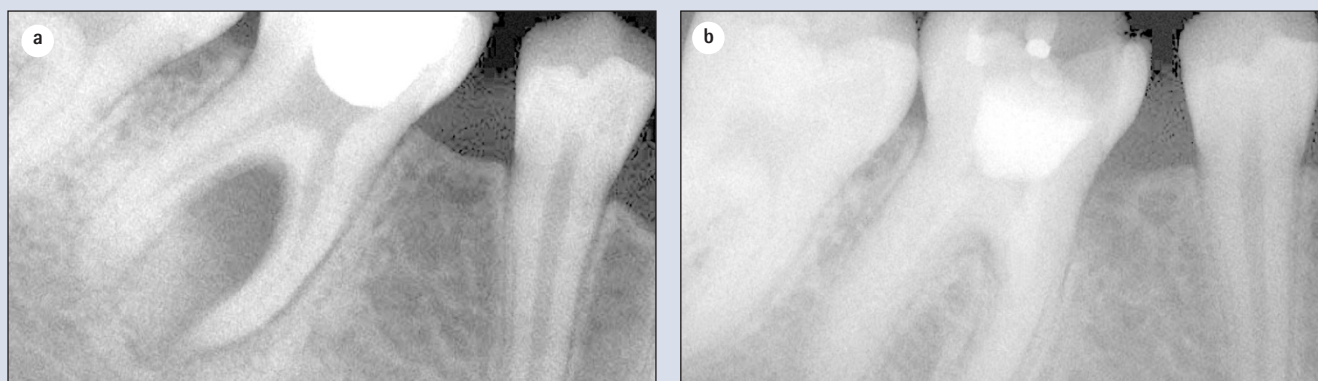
(a) The pre-operative radiograph of tooth LR6 (46) shows a large radiolucent area associated with the root apex and the furcation area. Root canal treatment was commenced. (b) A radiograph 6 months later when
